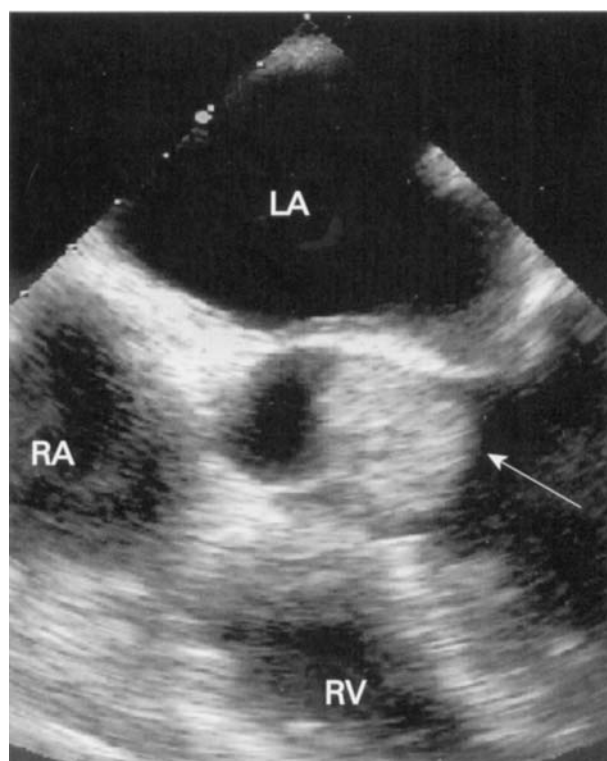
Infective endocarditis of the aortic valve. Mid-oesophageal view of the aortic valve at a multiplane angle of 0° (horizontal plane), showing a large vegetation (arrow) adherent to the ventricular aspect of the aortic valve prolapsing into the left ventricular outflow tract during diastole. Colour flow Doppler revealed severe aortic regurgitation. LA = left atrium, RA = right atrium, RV = right ventricle.
